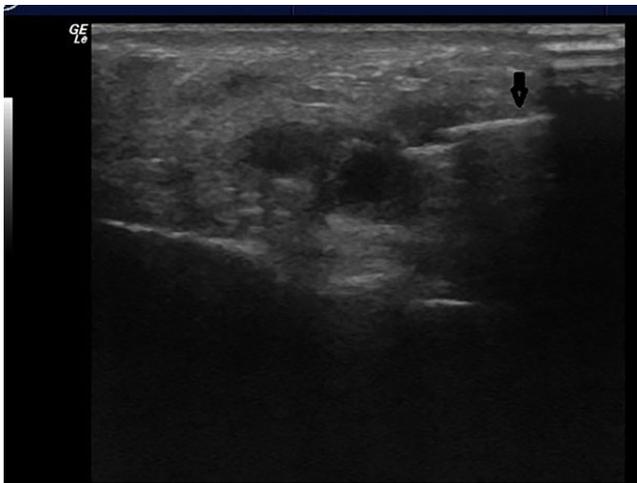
Under ultrasound guidance the needle is inserted in the filler deposit top right
